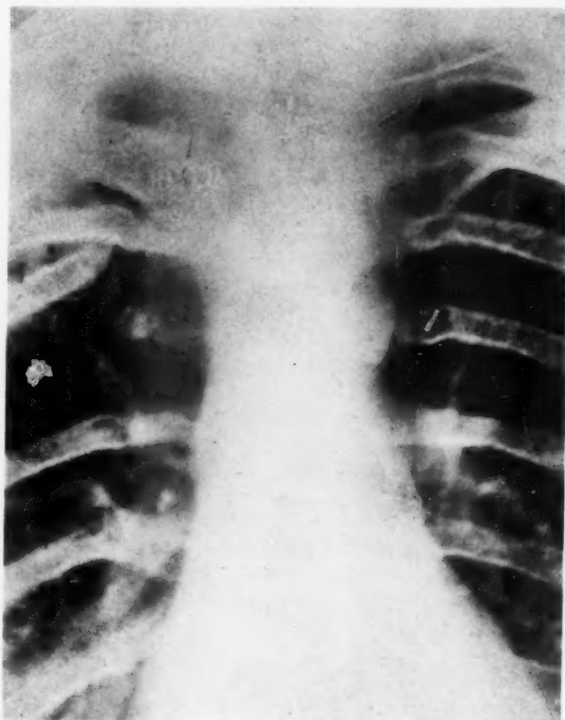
Follow-up anteroposterior roentgenogram showing area previously occupied by the tumor.
